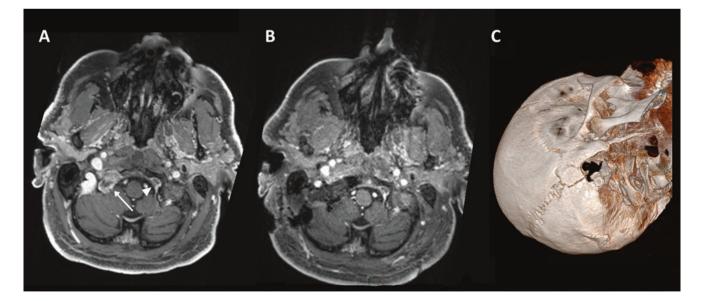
(a–c). Chordoma presenting unusual extension pattern and resection through keyhole far-lateral craniectomy. (a). MRI of a 59-year-old patient presenting with a late recurrence of a right jugular foramen chordoma (*arrow*) with extension to the contralateral hypoglossal canal (*arrowhead*). Clinically, the patient had complete right hypoglossal nerve
